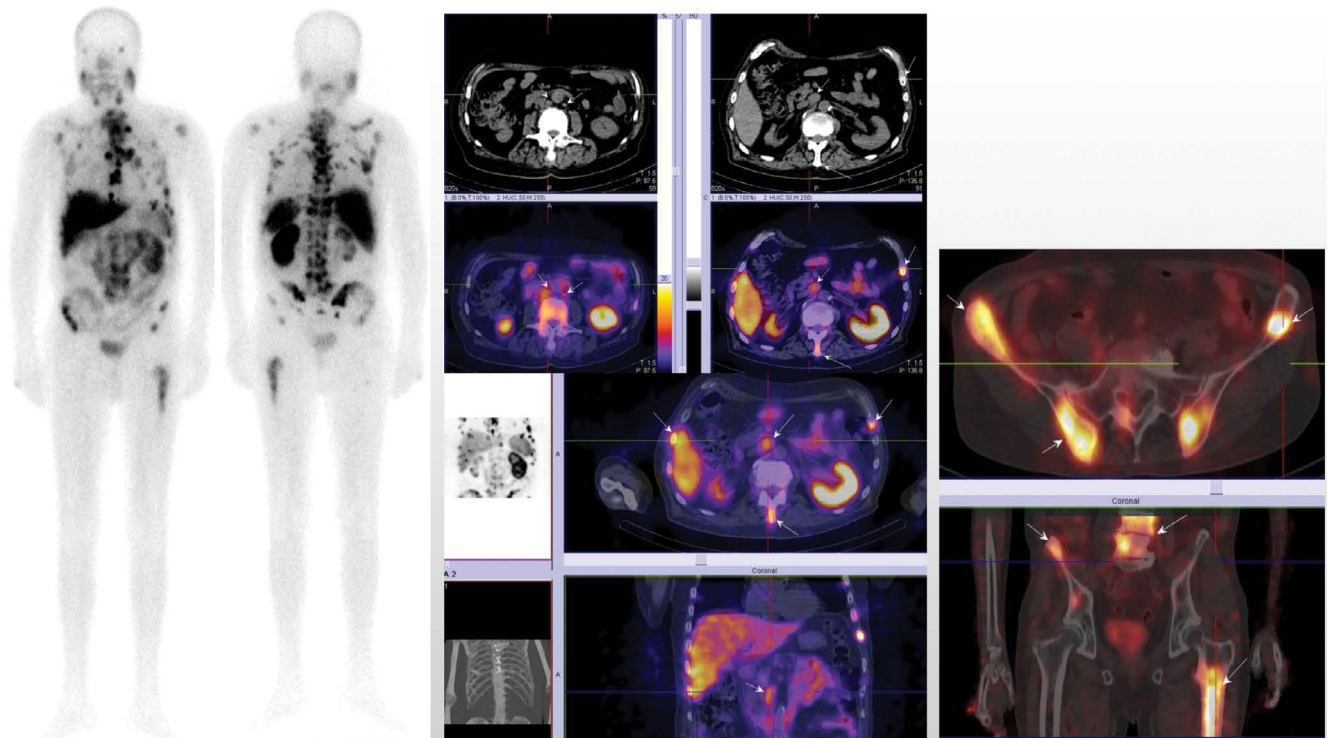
M/71yr with prostate cancer T3N0M0, G3, Gl = 8 (4 + 4). Radiotherapy definitive (09/2013). Androgen deprivation therapy. Chemotherapy and osteomodulators. PSA = 73ng/mL (02/2019). Whole-body scan and target [^{99m}Tc]Tc-PSMA-T4 SPECT-CT imaging showed multiple bone metastases and enlarged retroperitoneal lymph node metastases with intensive tracer uptake
